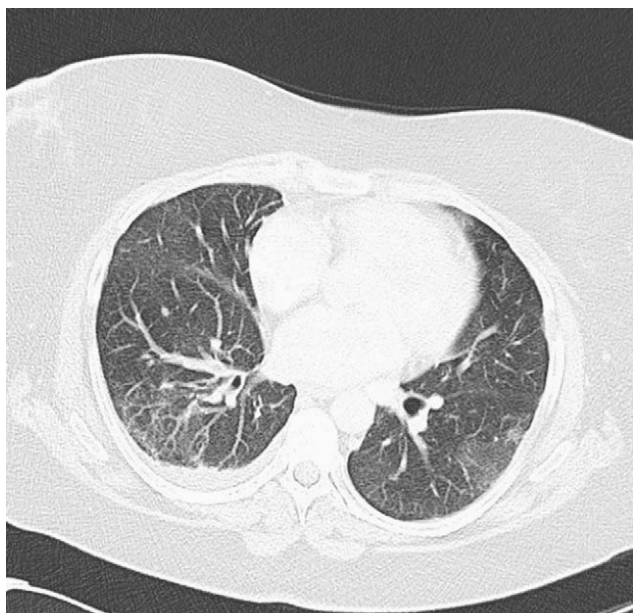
Computed tomography of thorax; sections from (a) upper and (b) lower lobes.
